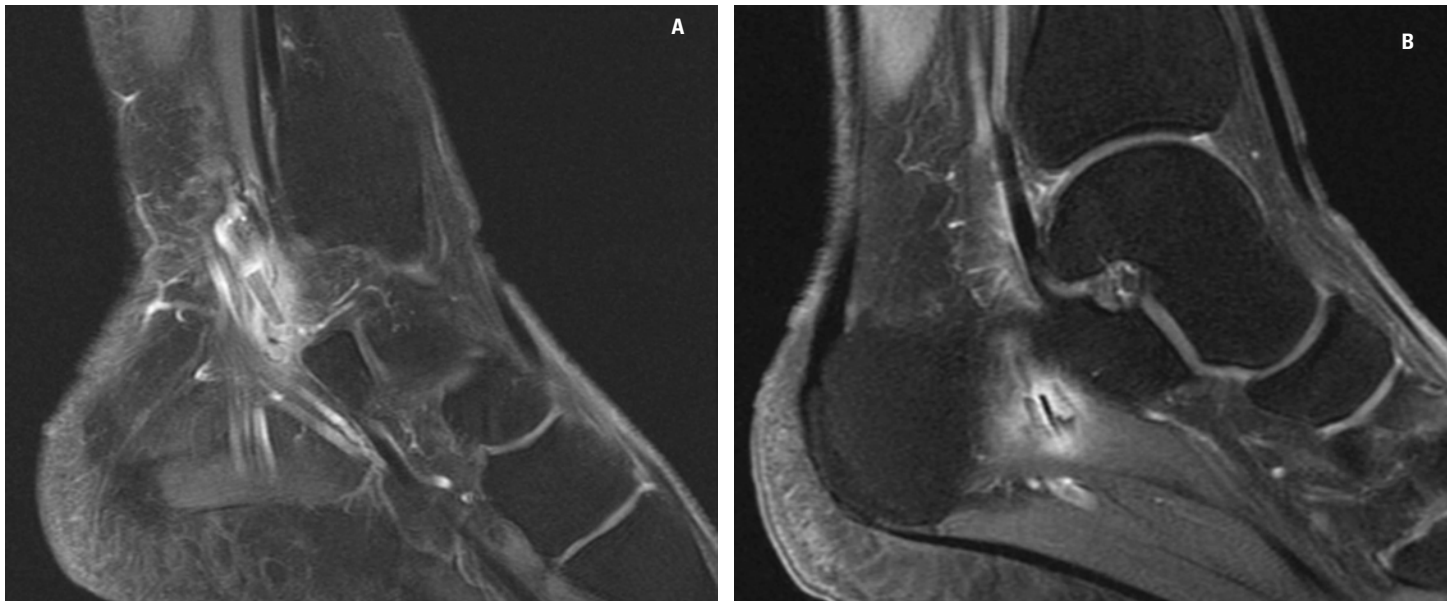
Sagittal T2 MRI, showing (A) 2-3 thin, linear low signal intensity foci within the quadratus plantae muscle, compatible with foreign bodies; (B) A large linear low signal intensity focus within the tarsal tunnel, compatible with a foreign body.
